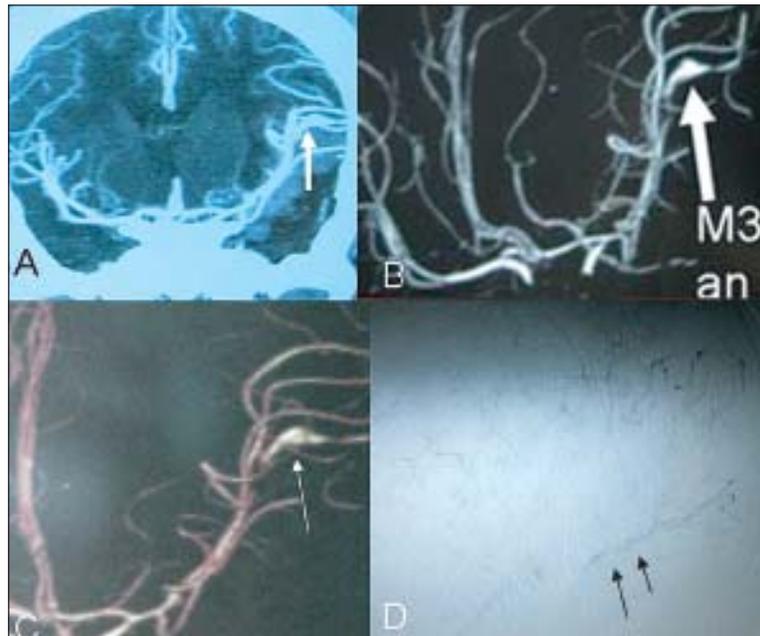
(A, B & C): CT angiogram of brain showing left sided M3 dissecting aneurysm (arrow marked). (D) Cerebral DSA showing slow and late retrograde filling of involved left distal M3 and M4 (arrows marked) form cortical anastomosis.
